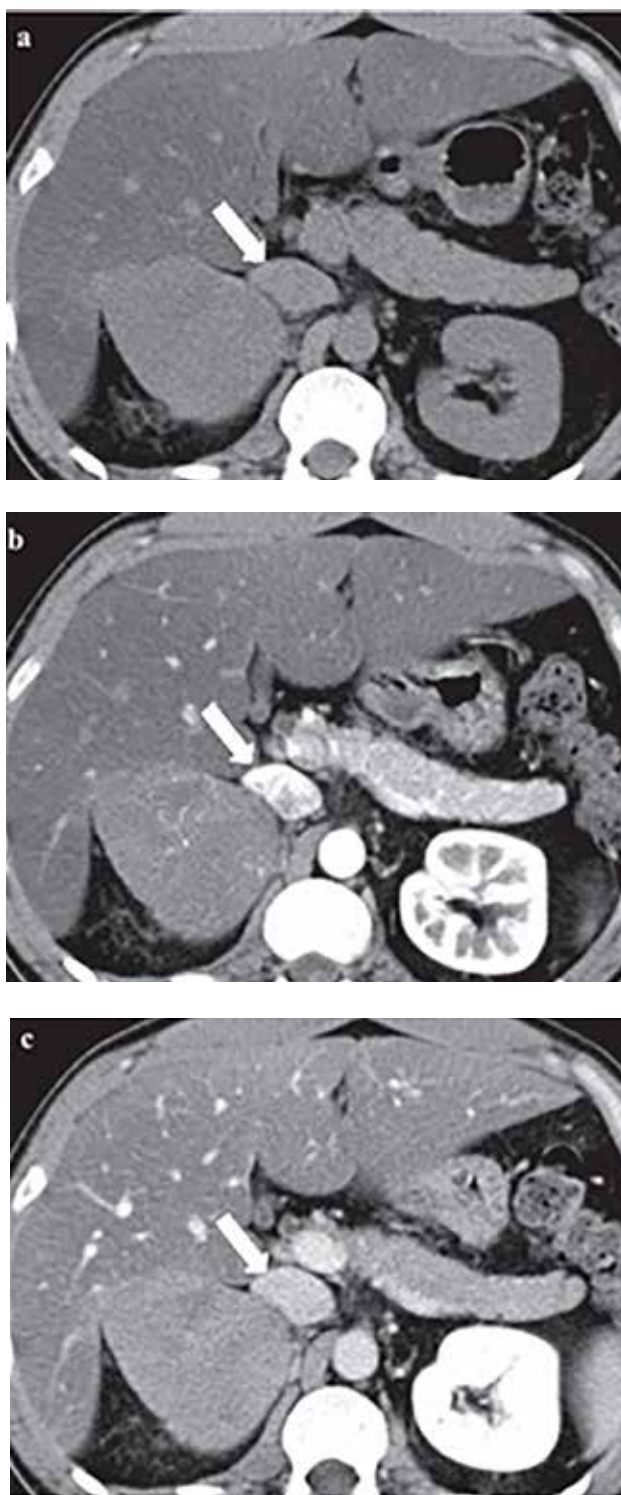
A well-defined homogeneous lesion (arrow) is displayed on axial native CT (A). After injection of the contrast material, slight enhancement of the tumor is observed during arterial phase (B) and delayed phase (C). These features are indicative of Schwannoma. (Suzuki K, Nakanishi A, Kurosaki Y, Nogaki J, Takaba E. Adrenal schwannoma: CT and MRI findings. *Radiat Med* 2007; 25: 299-302)
